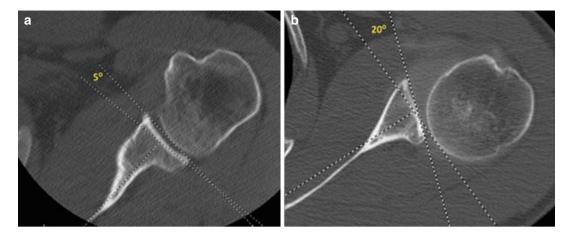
Axial CT images. (a) Normal glenoid retroversion. (b) Increased glenoid retroversion
